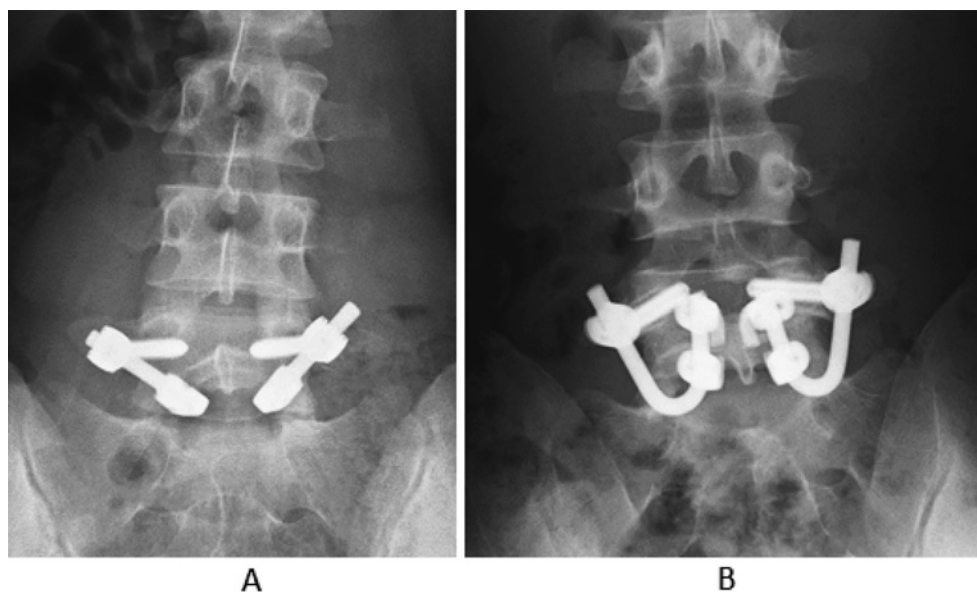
Antero-posterior radiographs of pedicle screw hook fixation (A) and pedicle screw claw-hook fixation (B).
